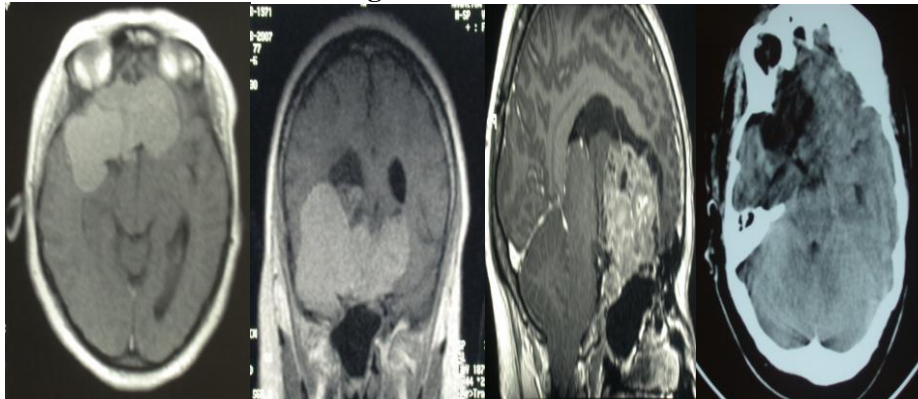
MRI images in sagittal, coronal and axial cuts showing a giant adenoma with significant lateral extension to the right and towards the third ventricle.
